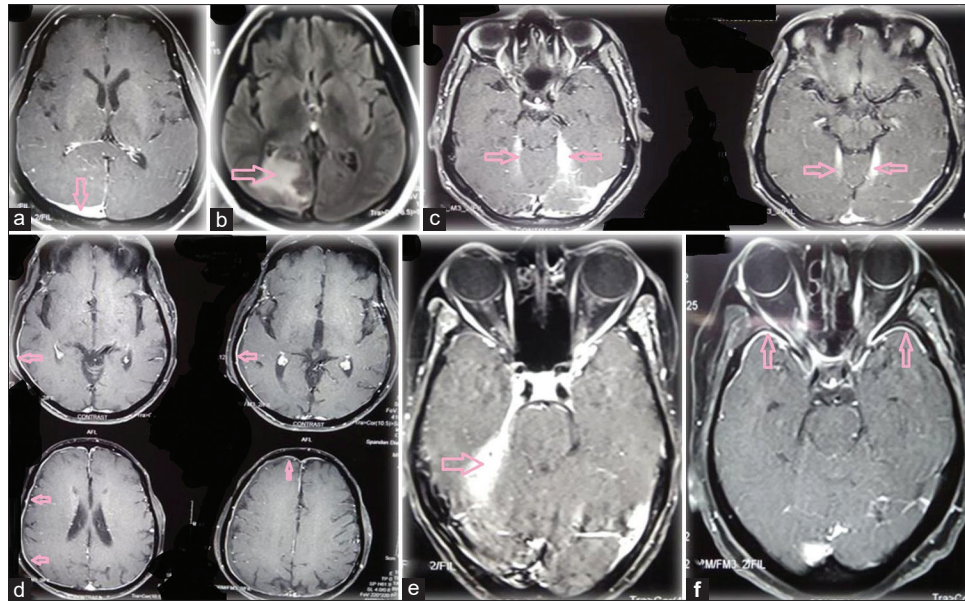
Focal regular HP. (a) T1 contrast image, (b) T2 FLAIR image: patient with idiopathic HP involving the right occipital region (focal regular enhancement) with edema in the adjacent cortex, with mild mass effect (marked with pink arrows). (c) T1 contrast image: bilateral tentorial focal regular enhancements in a patient with TB HP (marked with pink arrows). (d) T1 contrast image: right-sided frontal, parietal, and temporal focal regular pachymeningeal enhancements in a patient with idiopathic HP, presenting with right hemicranial headache (marked with pink arrows). (e) T1 contrast image: patient with idiopathic HP with right tentorial and bilateral anterior temporal region focal regular enhancements (marked with pink arrows)
